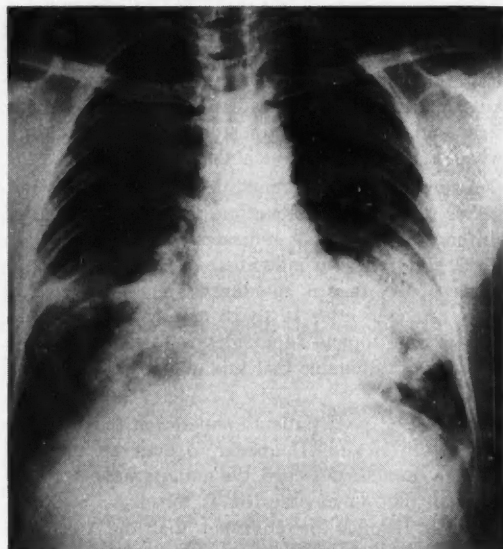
X-ray film of chest December 3, 1951, showing bilateral diffuse pneumonic infiltration.
